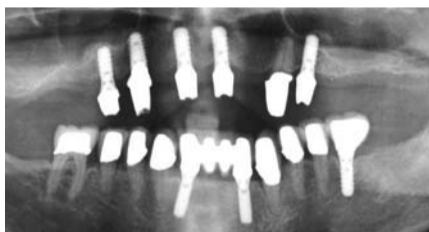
a & b) : Abutment mounted on the implant; c) panoramic radiograph of custom-made abutment #13 in place
